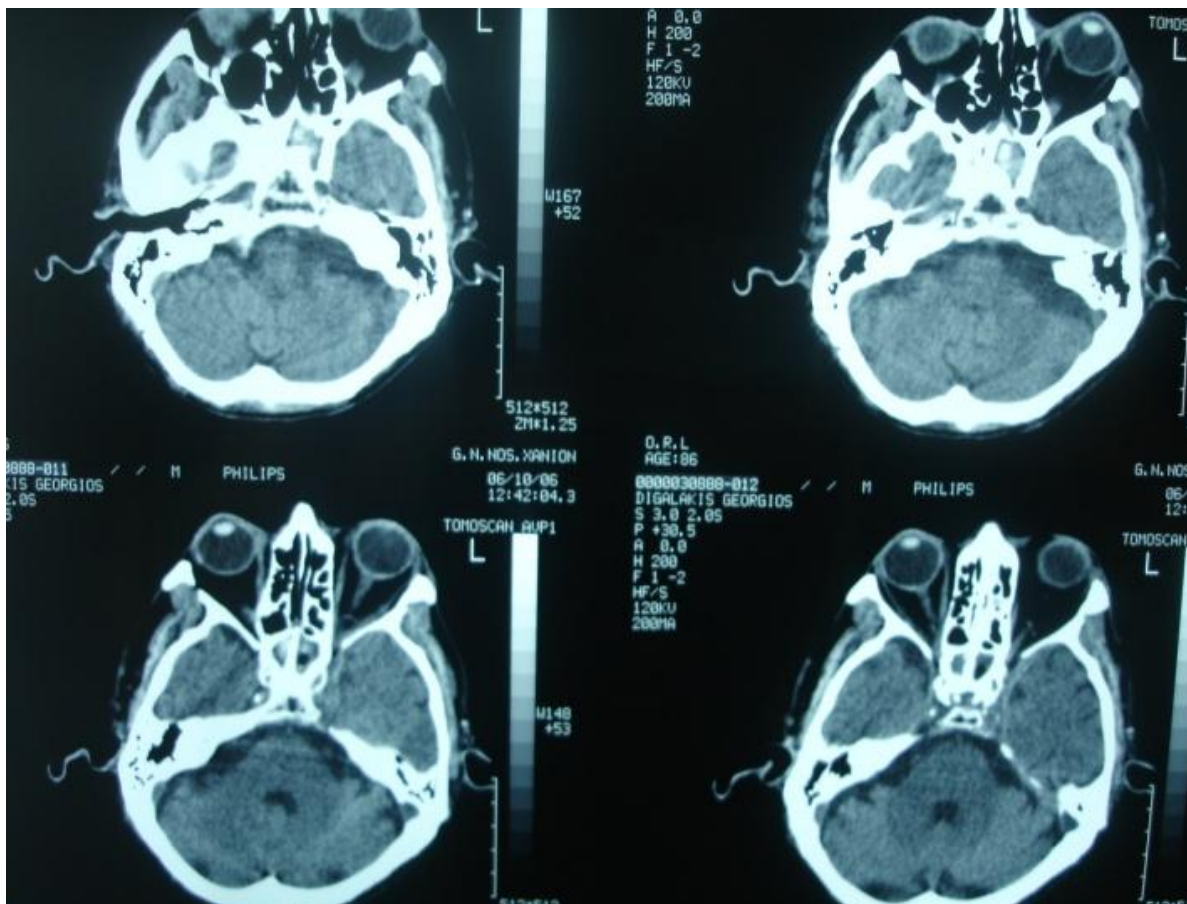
CT image - sphenoidal sinusitis
